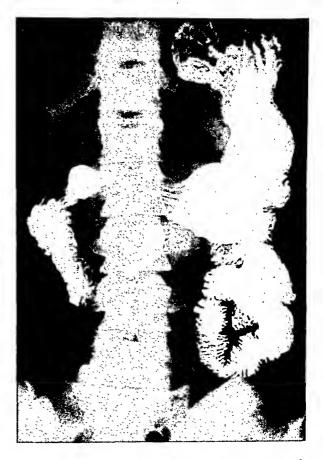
Carcinoma of the pancreas. Metastatic glands at the root of the mesentery produced the stasis shown in this roentgenogram.
